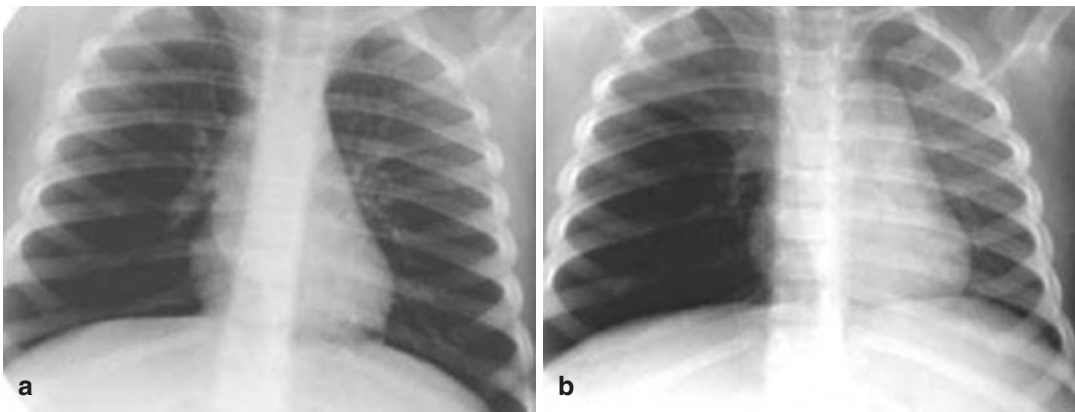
Foreign bodies in the airway of a 14-month-old patient with a history of penetration syndrome. Chest x-rays obtained on inspiration (a) and expiration (b) show greater transparency in the right lung. On expiration, air trapping in the right lung is evident and is due to the valve mechanism, which determines a mass effect of that lung
